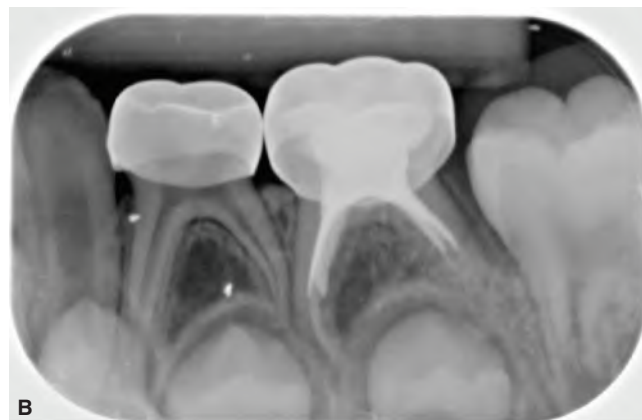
A. Successful root canal treatment in a maxillary central incisor. Note the root filling material that has extruded through a sinus track. B. Postoperative periapical radiograph of a root canal treatment in a primary mandibular left second molar. Note the interradicular radiolucency distal to the mesial root. Also, the end point of the root filling material is at the anatomic apex. C. Radiograph after 6 months of root canal treatment in the mandibular second molar. Note that the radiolucency distal to the mesial root is no longer present. (38-32A&B, courtesy of Dr. Moti Moskovitz, Jerusalem, Israel.)
